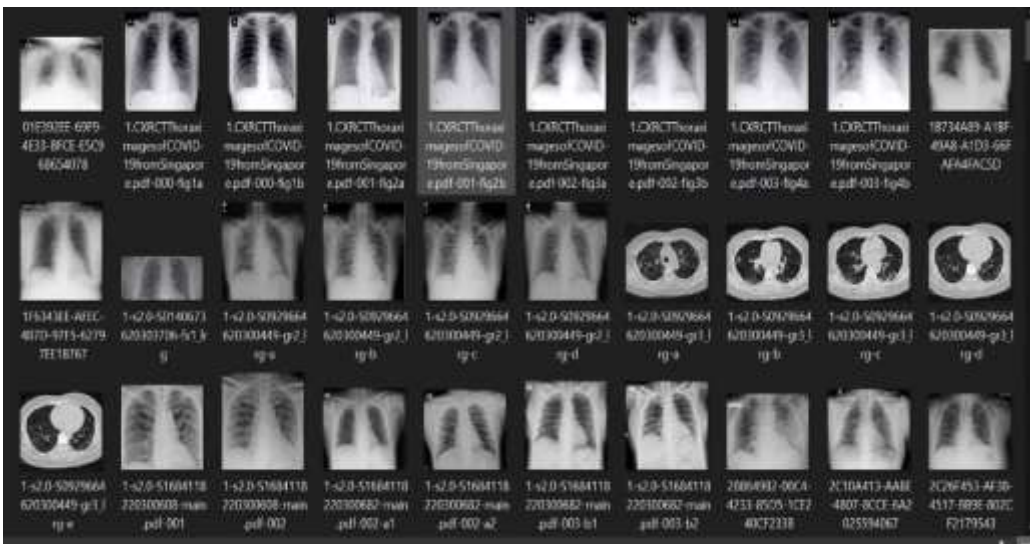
first 30 X-ray images of COVID dataset
